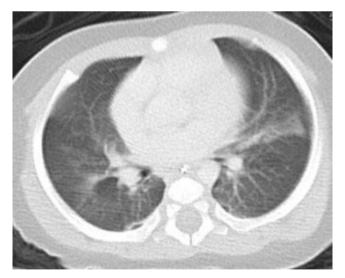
Axial HRCT showing patchy ground glass changes with underlying fibrotic scarring at right and left upper lobe with irregular interlobular septal thickening at 4th week of IV Ganciclovir
